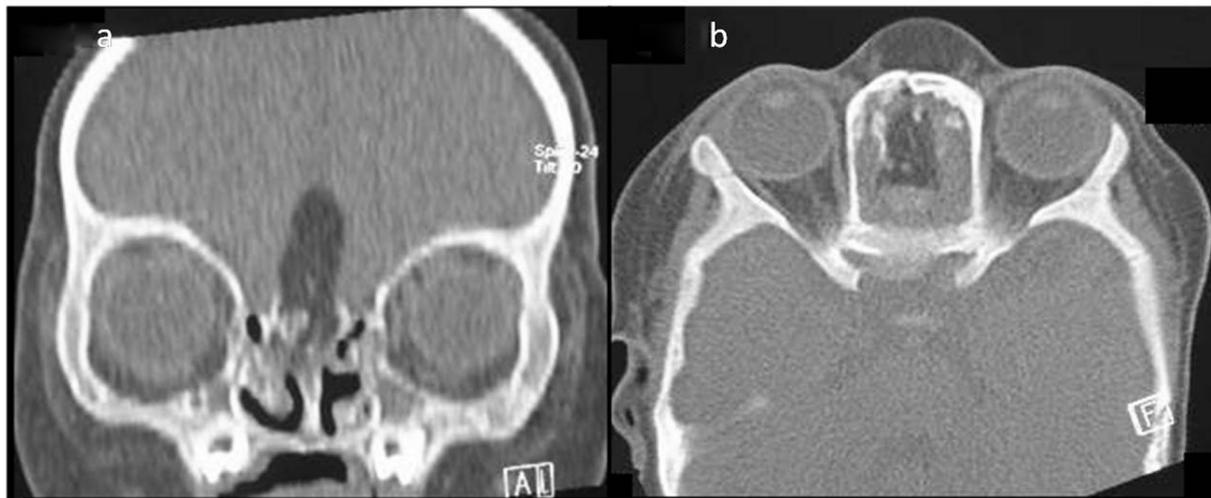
CT scan of the patient. a. Coronal CT scan showing the lipoma communicating with the intracranial compartment. b. Axial CT scan showing the anterior cranial fossa floor defect and communication of the lipoma into the subcutaneous compartment.
